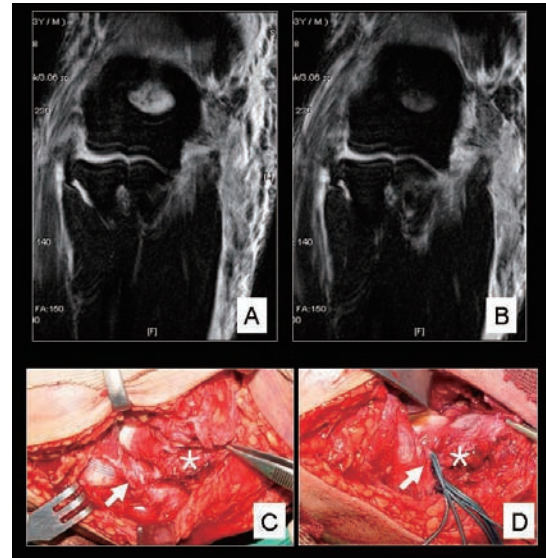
T2 weighted coronal MR images showed extensive soft tissue damage on both medial and lateral side with persistent subluxation. (A,B). At exploration, flexor/pronator tendon (arrow) was torn at musculotendinous junction and medial collateral ligament and capsule were avulsed from medial epicondyle (asterisk) (C,D). Both medial and lateral structures together with anterior capsule were repaired using anchor screws and bone tunnel method.
